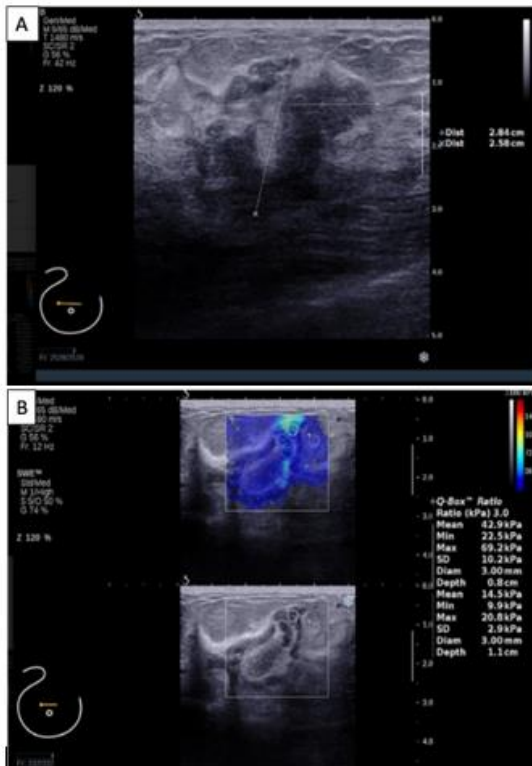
A. Ultrasound of the right breast shows a heterogenous hypoechoic mass with poorly defined margin and posterior acoustic shadowing. B. Shear wave elastography shows that the lesion is significantly stiffer than the normal surrounding breast tissue.
